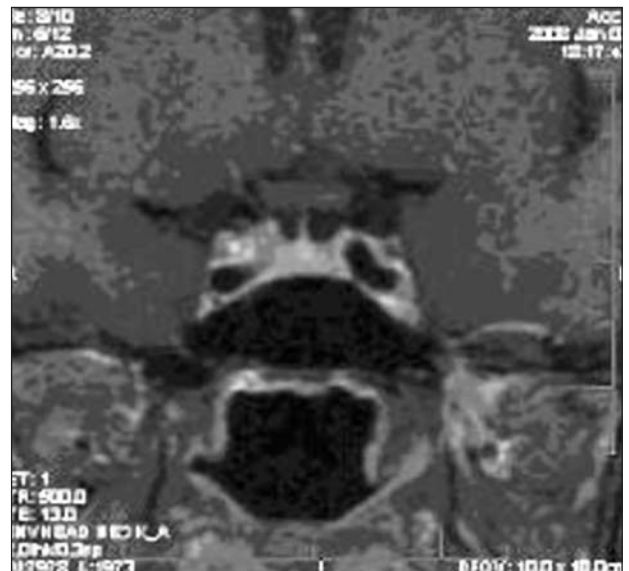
Conventional MRI Spin Echo demonstrating normal pituitary parenchyma
